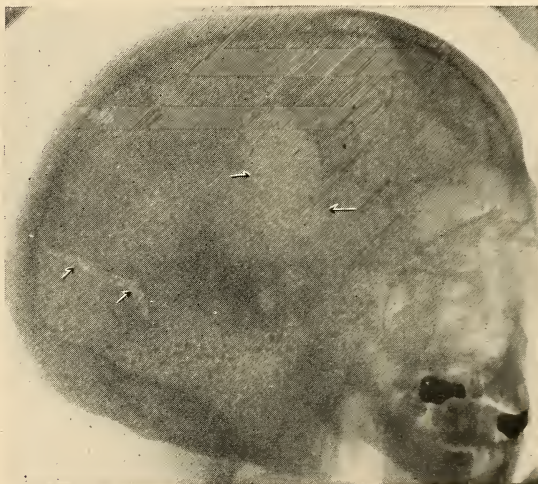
Lateral roentgenogram showing a linear fracture of the right occipital bone extending forward toward the right mastoid area. The bony defect of a right subtemporal decompression, with three silver clips clamping the dural vessels, can be seen. Patient has made an excellent recovery.
